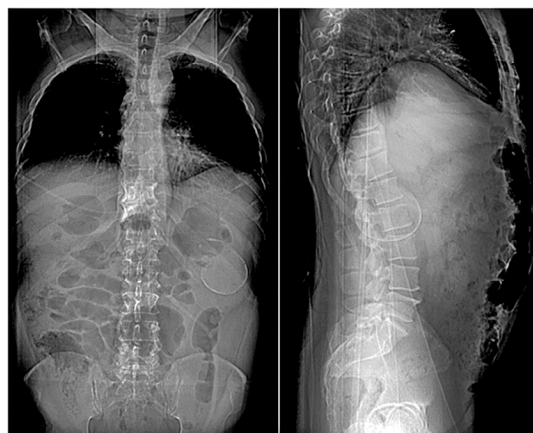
CT scout image depicting a calcified, cystic structure in the spleen.
